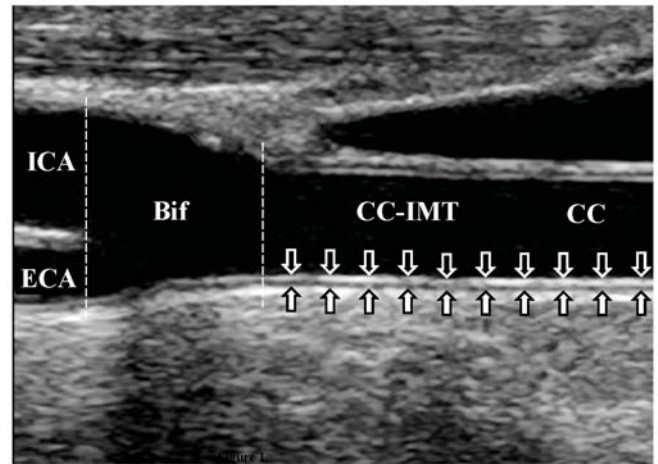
Typical ultrasound image of an extracranial carotid artery where the common carotid artery (CC), the bifurcation (Bif), the internal carotid artery (ICA) and the external carotid artery (ECA) are easily recognizable. The intima-media thickness (C-IMT) is delimited by black and white arrows.
